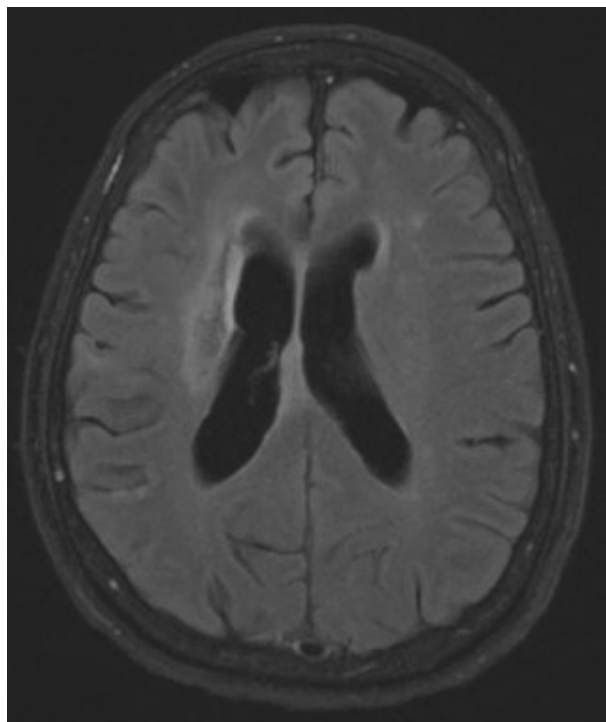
Follow up MRI brain after treatment with steroids demonstrating resolution of the vasogenic edema and inflammation, with persistent encephalomalacia from infarcted tissue.
